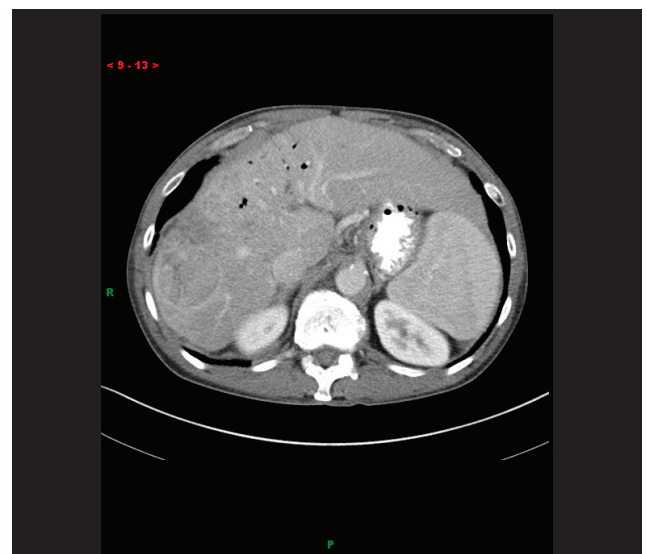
Hepatocellular carcinoma on CT scan in portal venous phase
